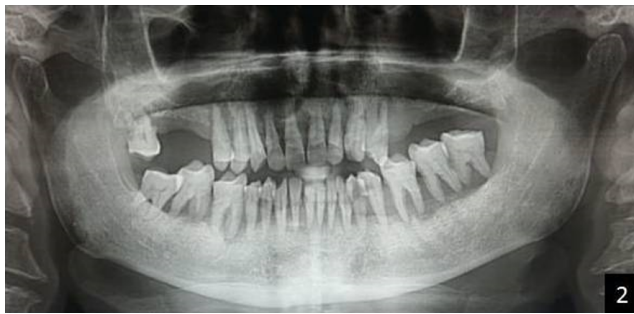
Orthopantomogram revealed presence of generalized bone loss
